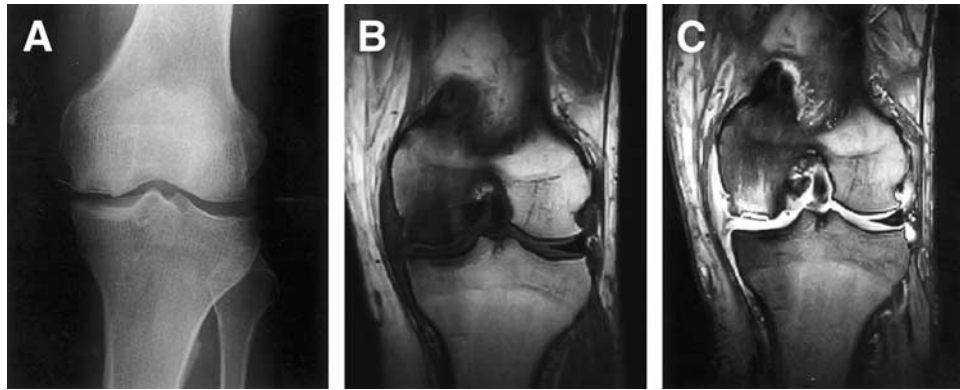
Radiograph and MRIs 3 months after meniscectomy. (A) Anteroposterior radiograph of the right knee shows subchondral flattening and collapse of the MFC. The lesion contained both radiolucent and sclerotic areas with a sclerotic halo. (B) T1-weighted MRI shows diffuse low signal intensity area in the MFC. (C) T2-weighted MRI shows localized low signal intensity area surrounded by high signal intensity area in the corresponding region.
